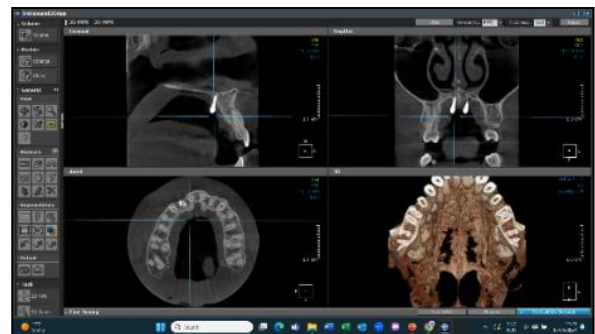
CBCT based palatal implant
